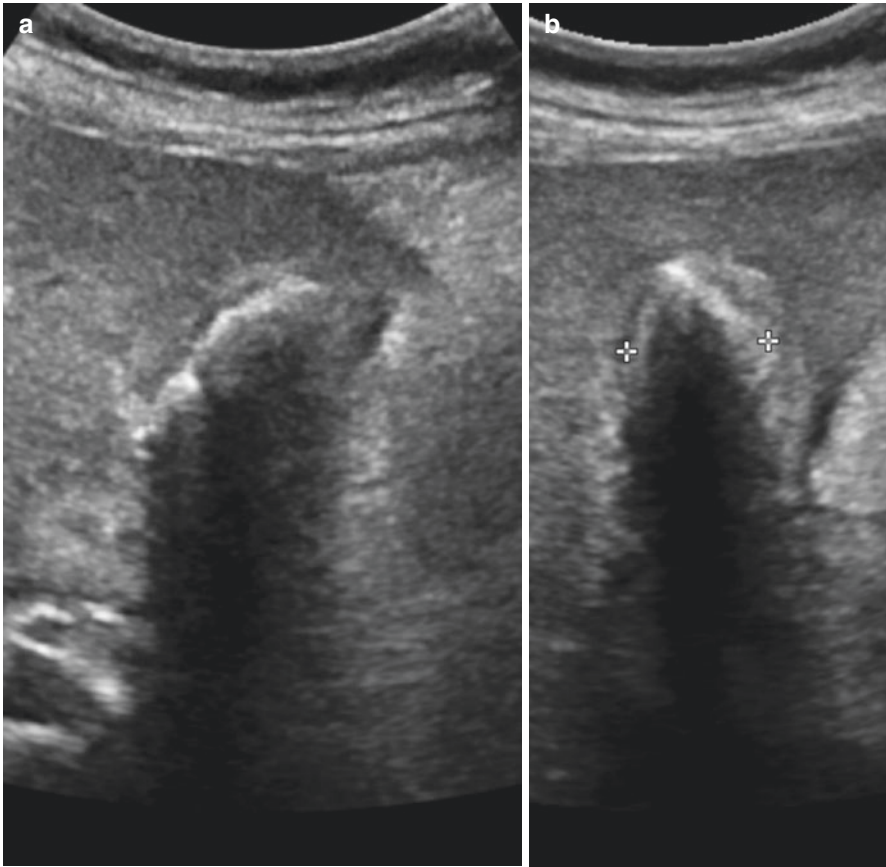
An ultrasound in a 62-year-old lady that had multiple previous episodes of biliary pain, some taking 2–3 days to resolve. The gallbladder is thick walled, contracted, full of stones with virtually no bile in the lumen on both sagittal (a) and coronal (b) views
